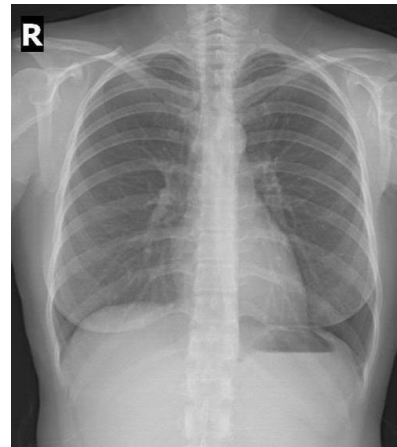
Postoperative 2nd month chest radiography
